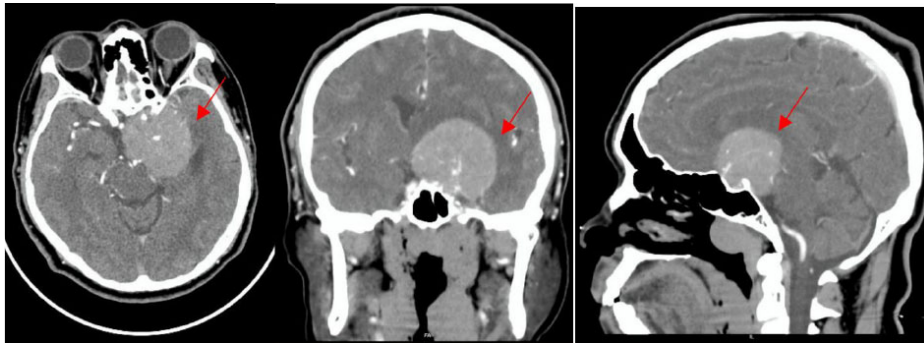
CT-Scan examination axial-coronal-sagittal section, solid mass in the left parasella that obliterated the cavernous sinus and optic chiasma, which extended to the left parietal, causing obstructive hydrocephalus and midline shift, suggesting a meningioma (red arrow).
